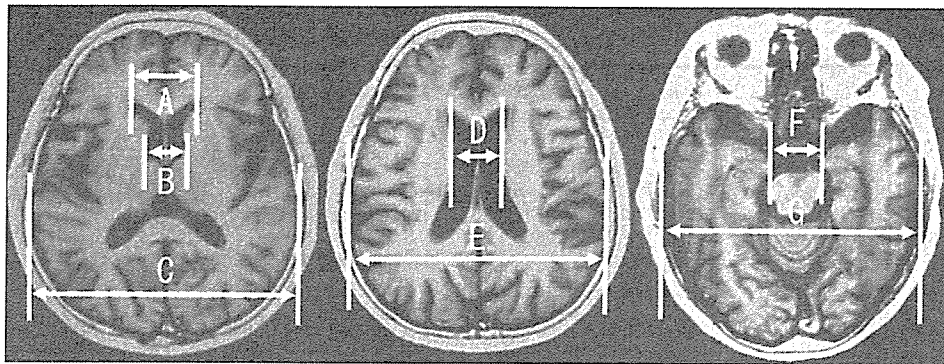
Measured portions on MR imaging. A, the maximum distance between the tips of the anterior horns; B, the width between the bilateral heads of the caudate nuclei; C, the maximum transverse inner diameter of the cranial space at the same MR section (left); D, the maximum width of the cella mediae; E, the maximum transverse inner diameter at the same section (center); F, the internal width between the bilateral temporal lobe at the level of basal cistern; G, the maximum transverse inner diameter at the same level (right). Evans ratio = A/C , caudate head index = B/C , inverse cella media index = D/E , basal cistern index = F/G
